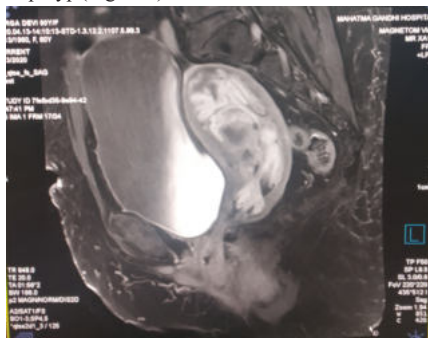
MRI Photograph Showing Abnormal Signal Intensity Polypoidal Mass In Endometrium
